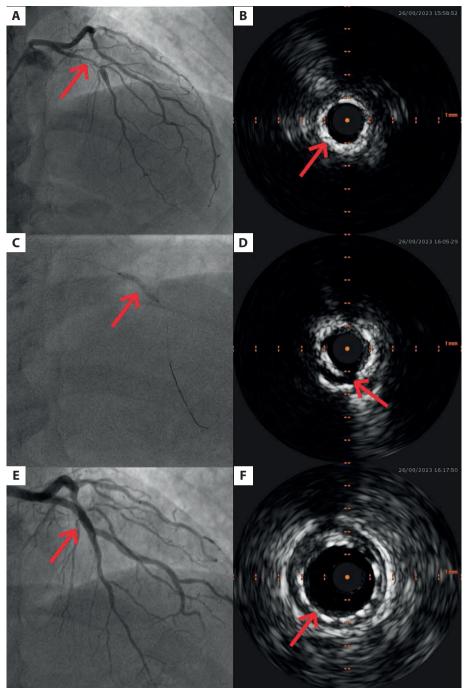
Percutaneous coronary intervention of the left anterior descending (LAD) artery with orbital atherectomy (OA). A. Angiography showing critical, calcified stenosis of the proximal and mid LAD (red arrow). B. Intravascular ultrasound (IVUS) showing circumferential, superficial, and deep calcifications in the mid-LAD part (red arrow). C. Severe underexpansion of the 2.5 mm non-compliant balloon on angiography after OA performed at 80 000 rpm (red arrow). D. Calcium crack confirmed on IVUS after several OA rounds at 120 000 rpm (red arrow). E. Final angiographic result (red arrow). F. Final IVUS result (red arrow)
